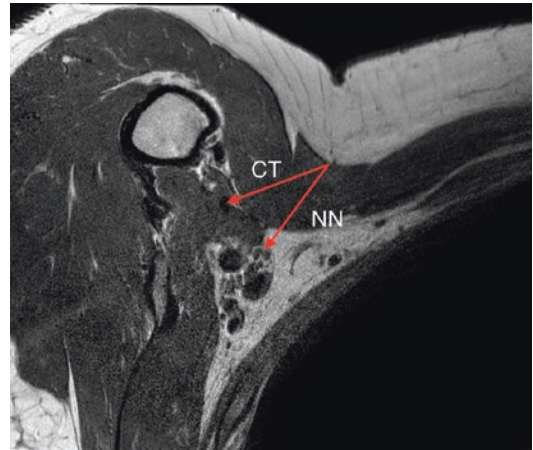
CT image of the nerves and conjoint tendon
